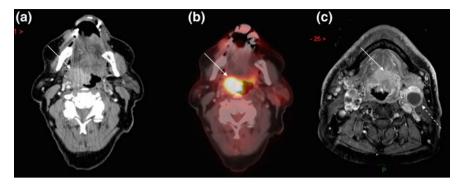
a Axial post-contrast CT shows tumor of right oropharyngeal wall (*arrow*). b PET-CT shows FDG avidity in the tumor (*arrow*). c Axial T1 post contrast shows base of tongue tumor (*arrow*) and necrotic left level IIa node (*dashed arrow*)
